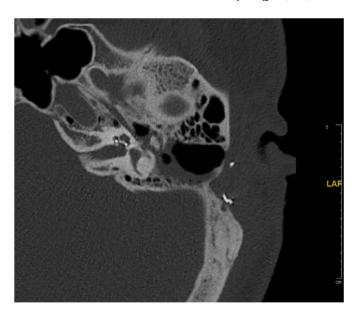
HRCT scan (axial view) reveals the electrode array within the vestibule.
